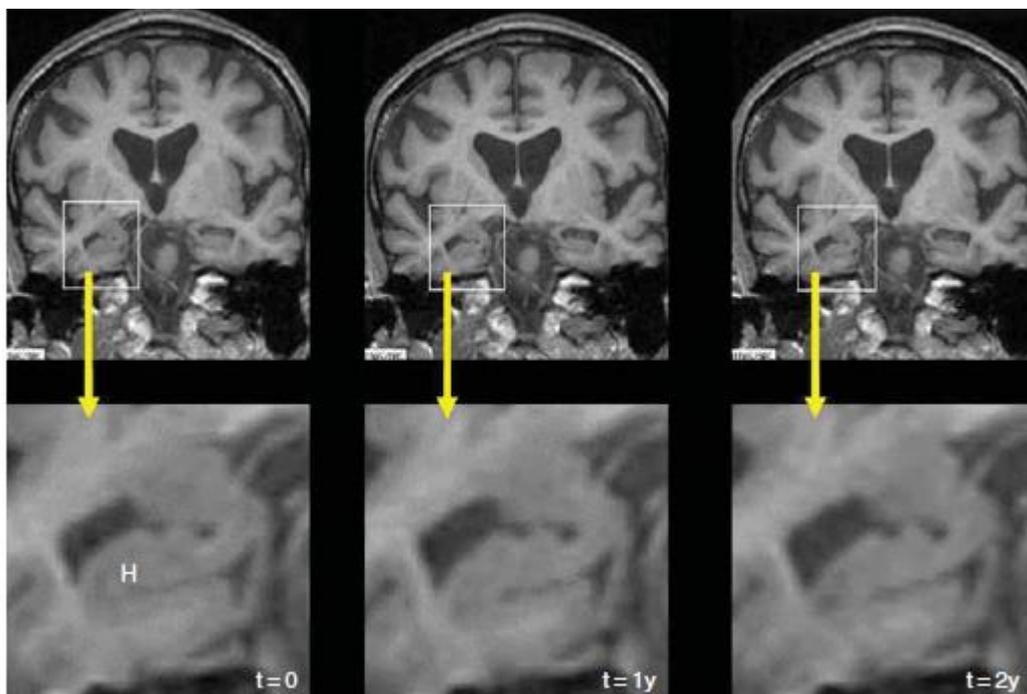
Three coronal T1-weighted images from an individual with autopsy-proven AD, were each acquired 1 year apart and show progressive hippocampal (H) atrophy as the individual progressed from memory complaints (left column, t=0) to MCI (center, t=1) and on to fulfill criteria for AD (right column, t=2). Johnson et al. Cold Spring Harb Perspect Med 2012; 2:a006213
